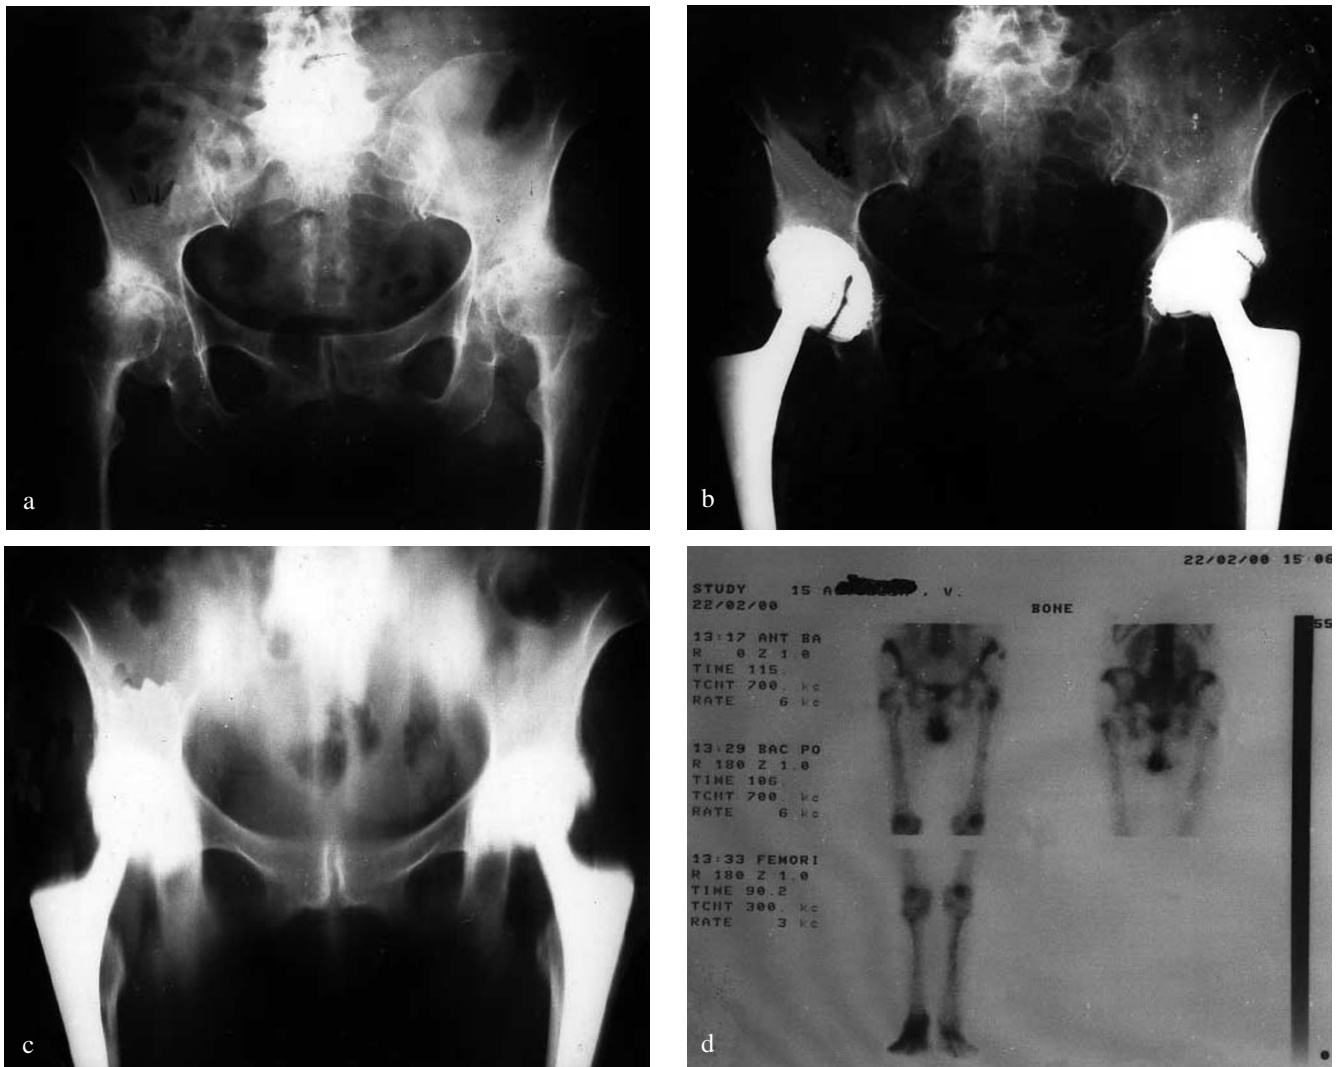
Patient with bilateral metal-on-polyethylene CLS acetabular components. a Preoperative radiographic view. b Follow-up radiograph (right side: 6 years postoperative; left side: 5 years postoperative) show good bone integration of the cup. c Postoperative tomography. d Postoperative scintigraphy showing no increased uptake in the hips
